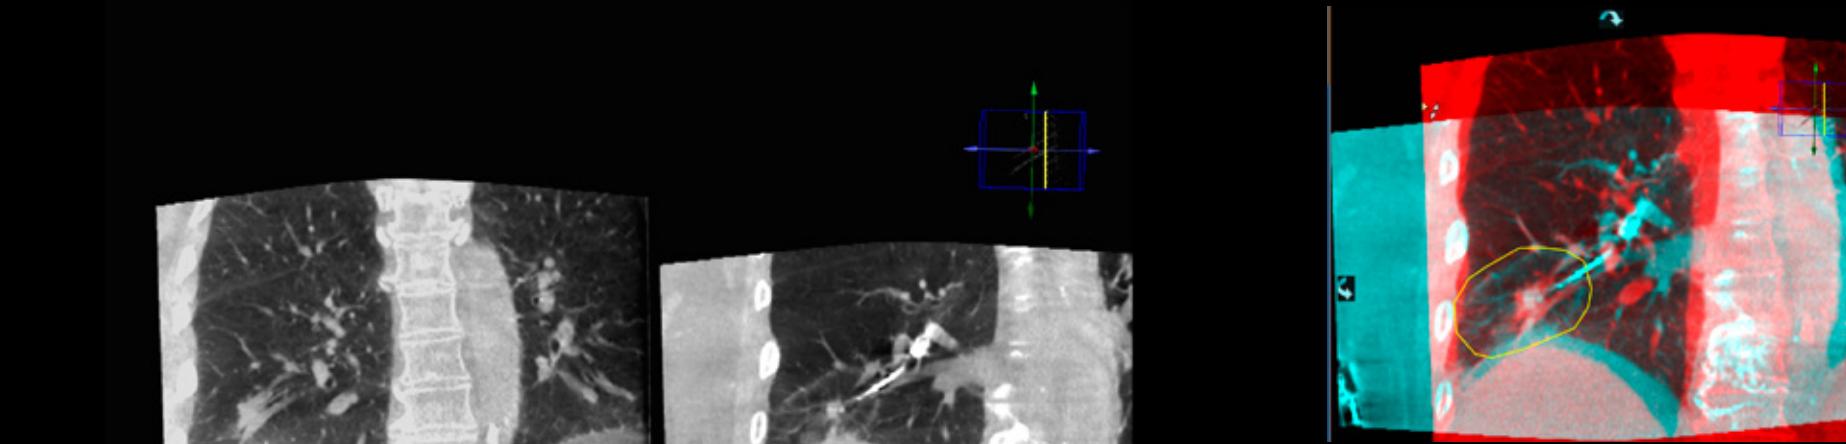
Comparison of pre and post-ablation cone beam CT volumes using Dual view functionality (left). Overlay viewer of the two cone beam CT volumes highlighting extent of ablated tissue in yellow (right).
